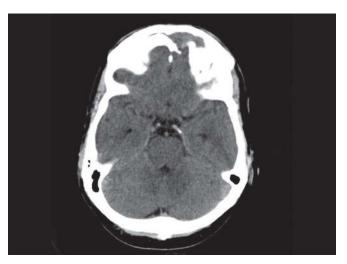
Axial cut of CT PNS showing dehiscent posterior wall of frontal sinus
